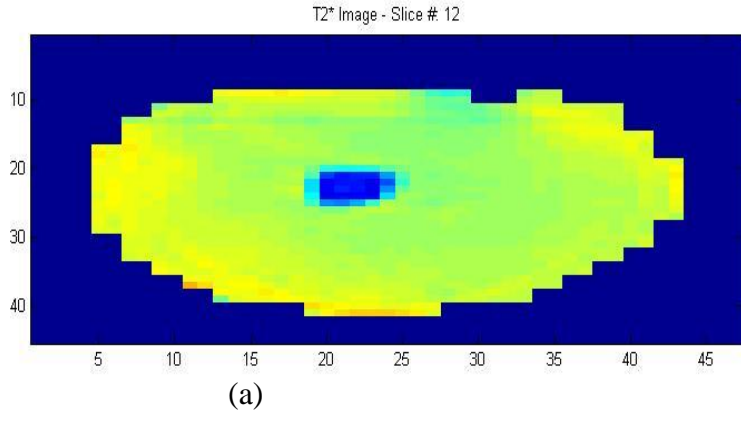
Reconstruction of Case 2 for slice 12 (a) MR image, (b) Shear modulus reconstruction, (c) Damping ratio reconstruction and (d) Rayleigh composition
